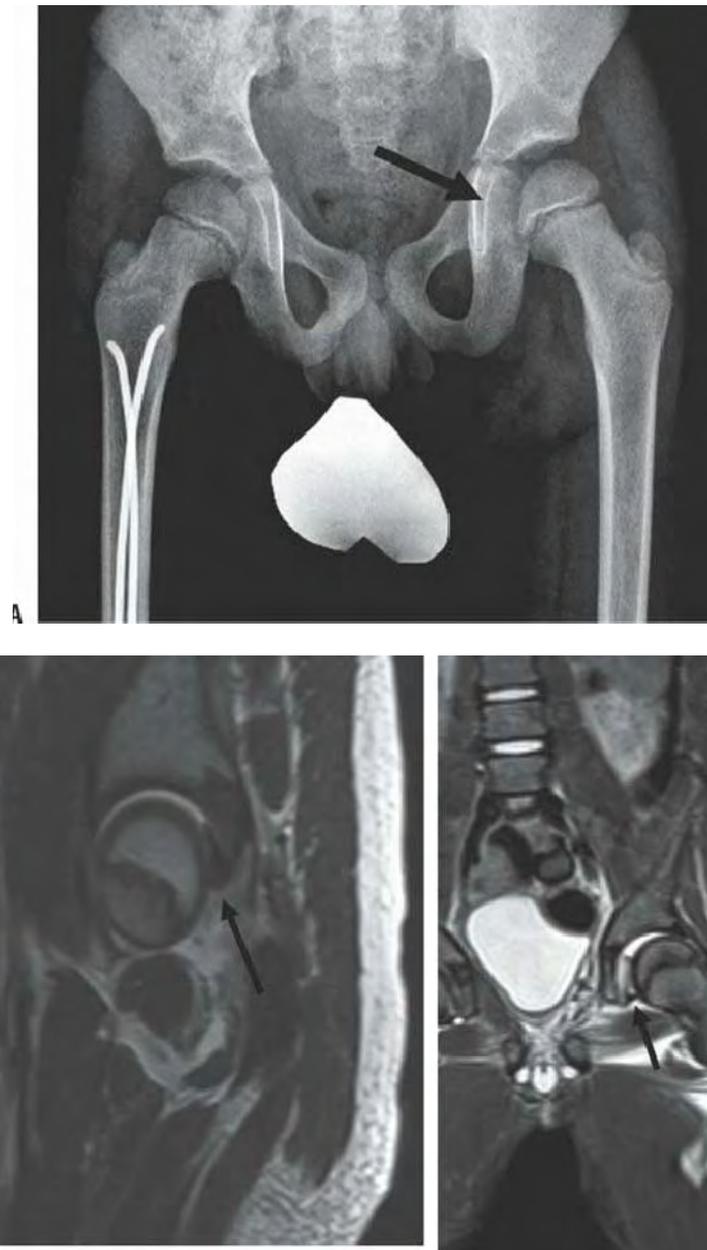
A: Pelvis x-ray of a 7-year-old. There is slight widening of the left hip joint (*arrow*) with no fracture visualized B: MRI of the hip showing soft tissue (labral/cartilage, *arrow*) not visible on plain radiographs entrapped in the posterior hip impeding reduction.
